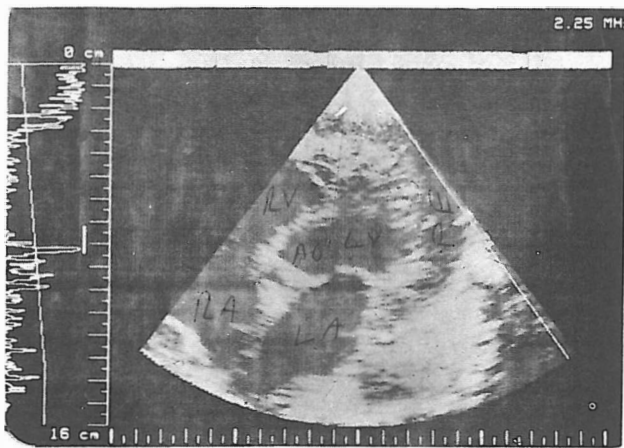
Another two-dimensional echocardiographic study revealing pericardial effusion.
